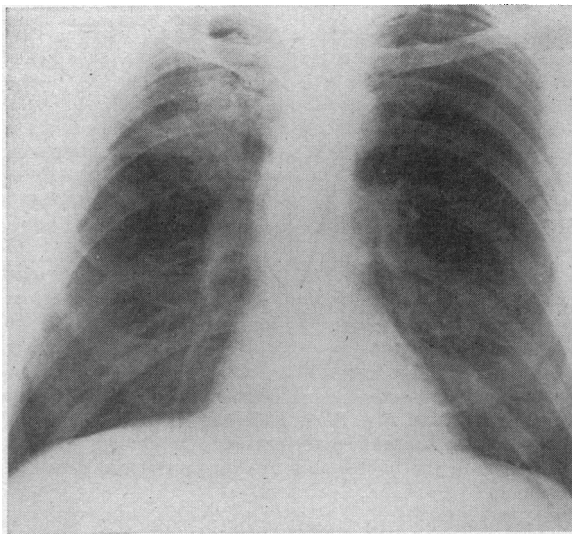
Case 2 (J. C. B.). Roentgenogram of chest (December 6, 1941), showing a density without borders in the right upper lobe, extending upward from the right lung root.
